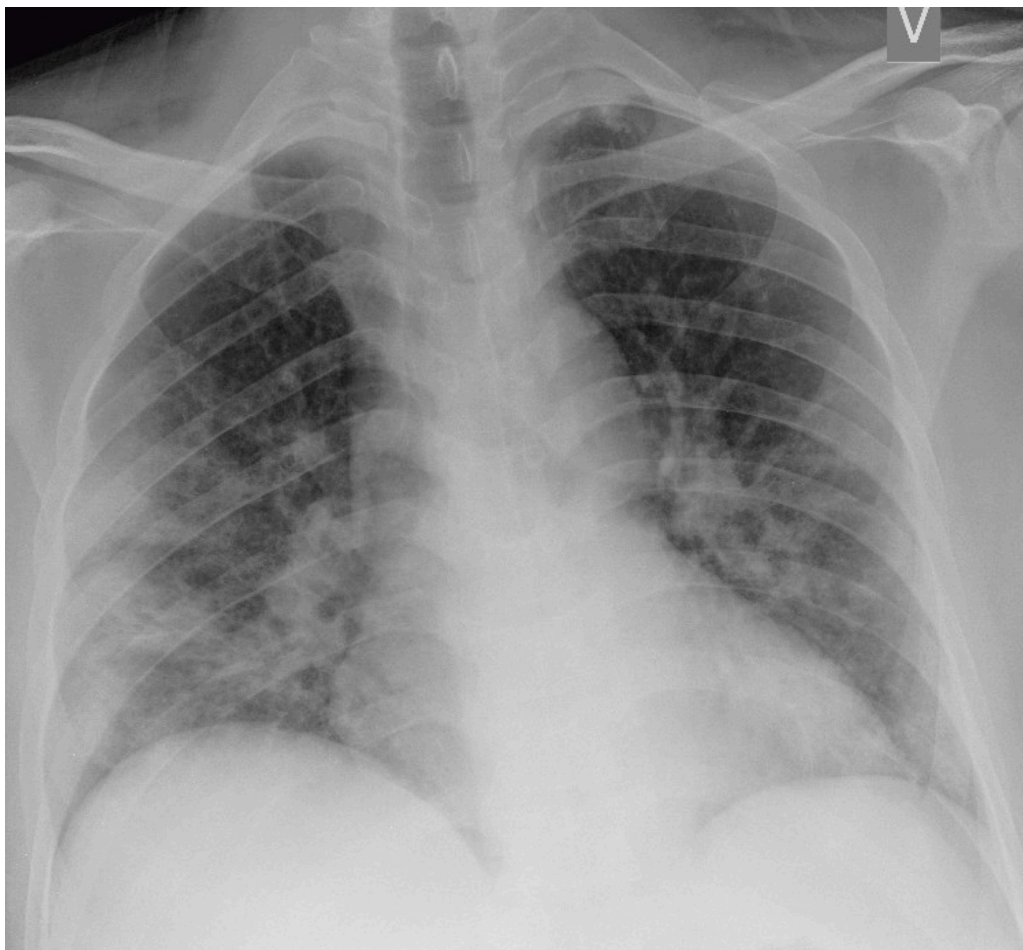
Patient with COVID-19 hospitalised with reduced general condition, dry cough and increasing dyspnoea. Prone bedside chest X-ray five days after symptom onset shows patchy opacities with right mid-zone predominance
